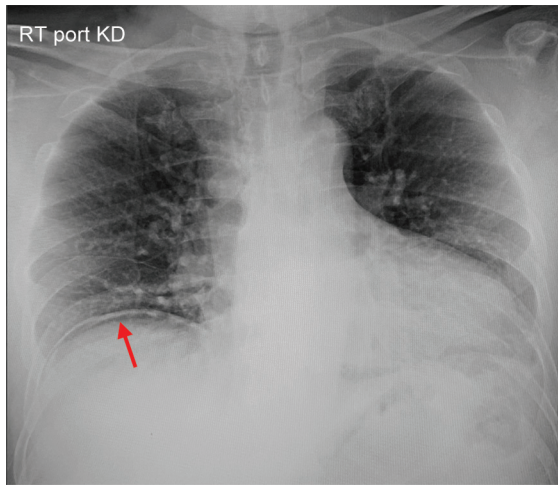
X-ray chest which demonstrated pneumoperitoneum at the red arrow
